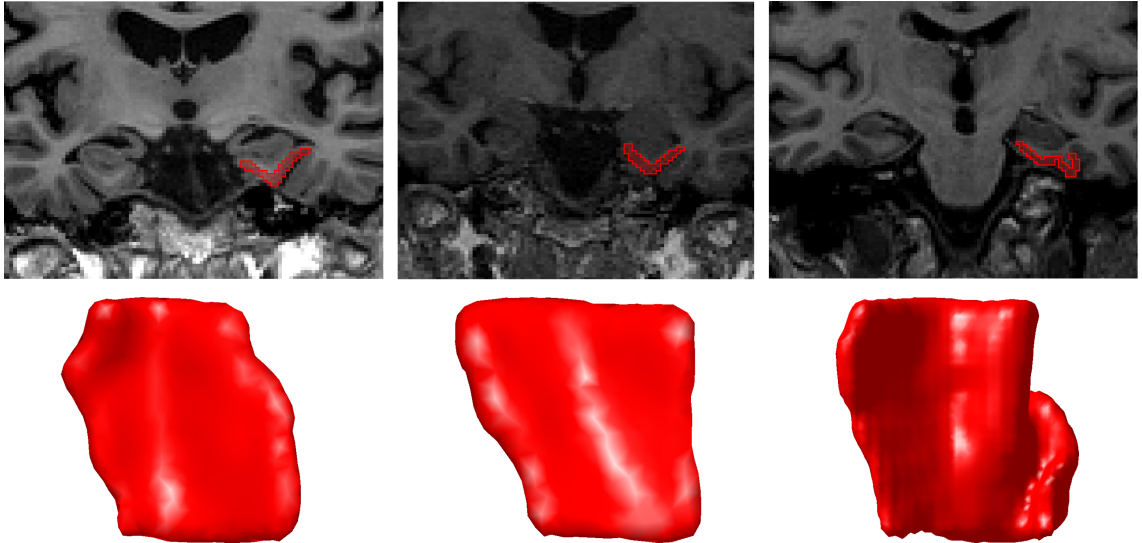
A coronal MRI section and corresponding surface of each CoS variant Type I (left), Type IIa (middle), and Type IIb (right). The surfaces are oriented such that left is medial, right is lateral, top is posterior, and bottom is anterior. Figure reproduced with permission.⁷⁰
